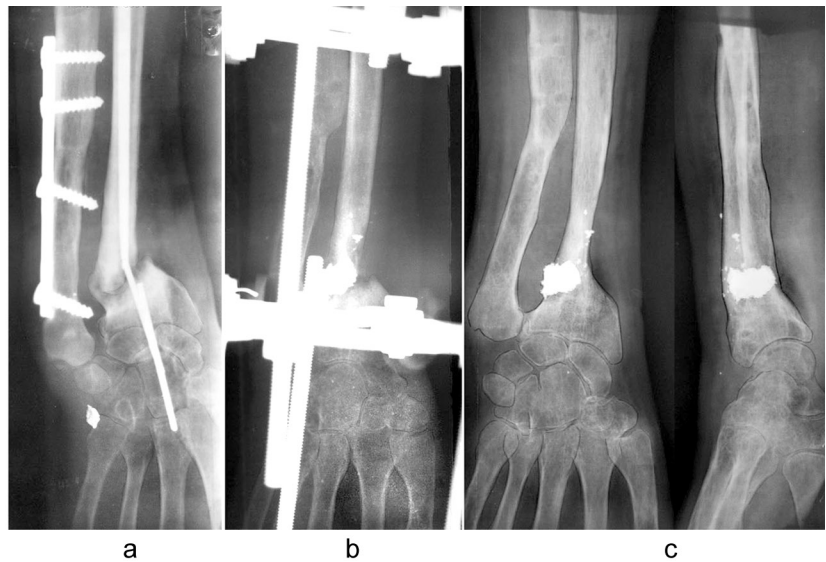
Radiographs of a 36-year-old patient P. with ulna fracture, comminuted compression juxta-articular fracture of the radius and dislocated ulna showing (a) broken IM nail, diastasis between radius fragments at 7 months of bone fixation; (b) Ilizarov external fixator applied and bone defect filled with porous implant at 2 weeks; (c) Ilizarov frame removed at 3 weeks
